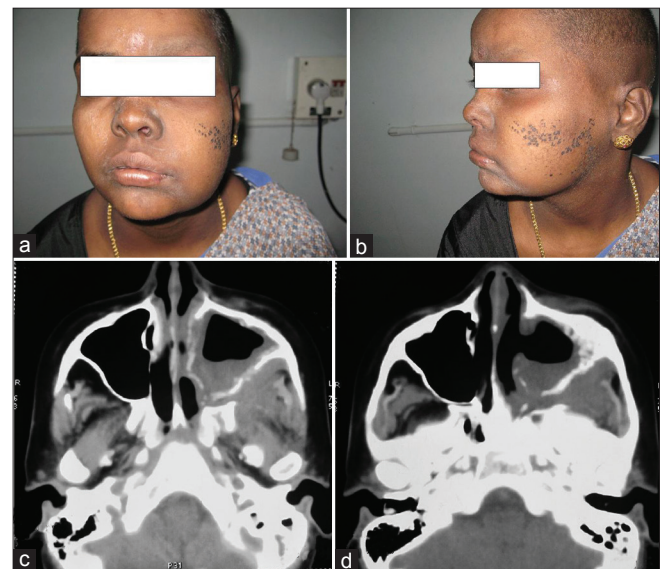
(a and b) Clinical photograph post-chemoradiation. (c and d) A post-therapy CT scan (after 6 months) showing only residual thickening of the left maxillary antrum
